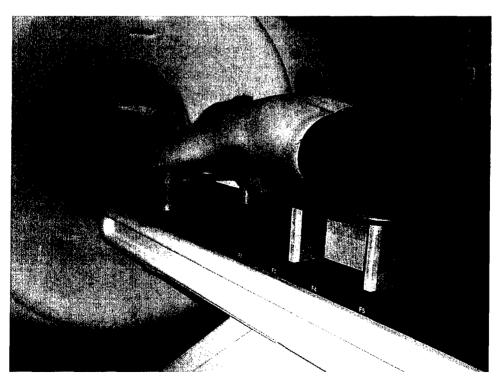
Patient undergoing computed tomography acquisition of images.
